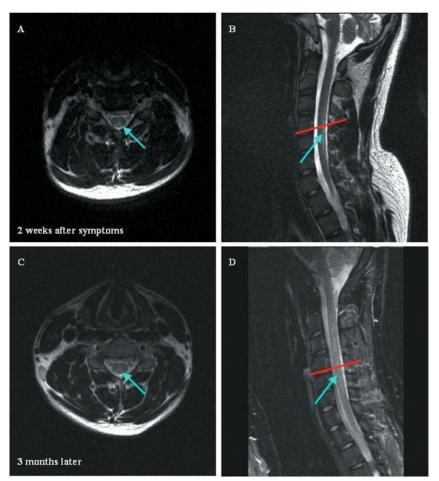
(A) (B): MRI of the cervical spine done two weeks after symptom showed long segmental hyperintensity change on T2WI at posterior column of spinal cord from the secondary to sixth cervical level (arrow), slightly more on the left and slightly fifth to sixth cervical level predominant. The lesion could be an inflammatory demyelination lesion or related to vitamin B12 deficiency. (C) (D): MRI of the cervical spine did three months later show faintly hyperintensity on T2WI at posterior paramedian spinal cord from the secondary to sixth cervical level. It is less prominent compared with the prior study.
